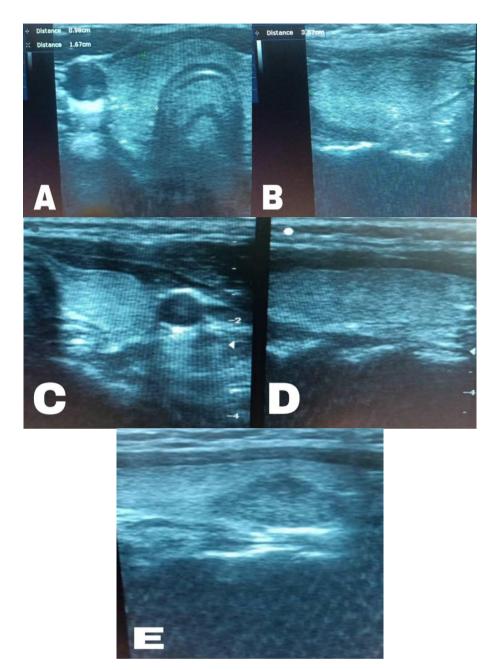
Ultrasound image of the thyroid gland. A – measurements of AP diameter and width of the right lobe on transverse scan. B – measurement of height of the right lobe on longitudinal scan. C – measurements of AP diameter and width of the left lobe on transverse scan. D – measurement of height of the left lobe on longitudinal scan. E – incidental finding of a mass
